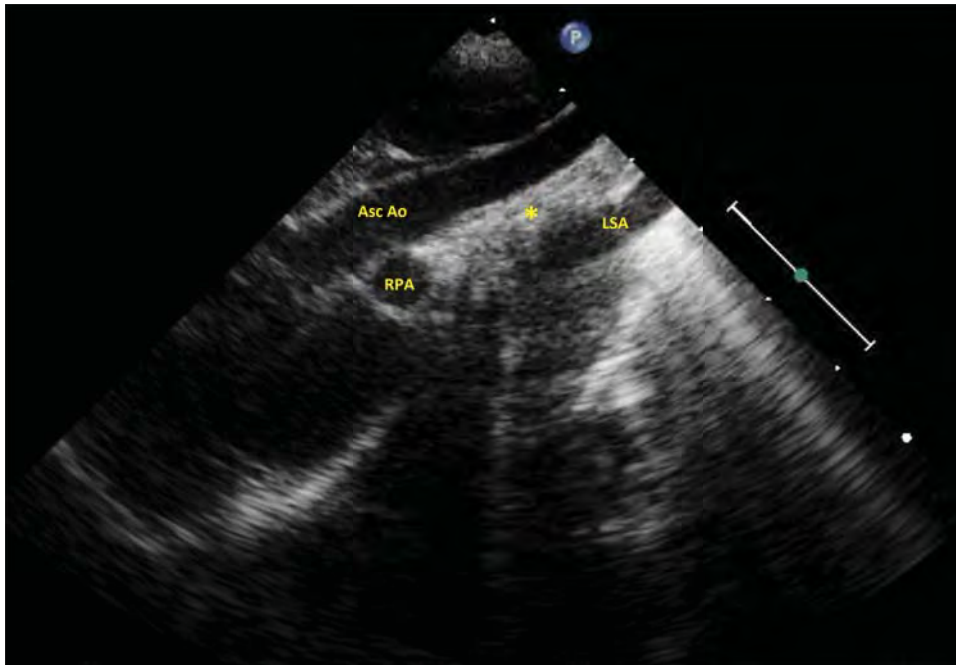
Transthoracic echocardiogram of type B interrupted aortic arch. Asterisk marks the site of interruption.
